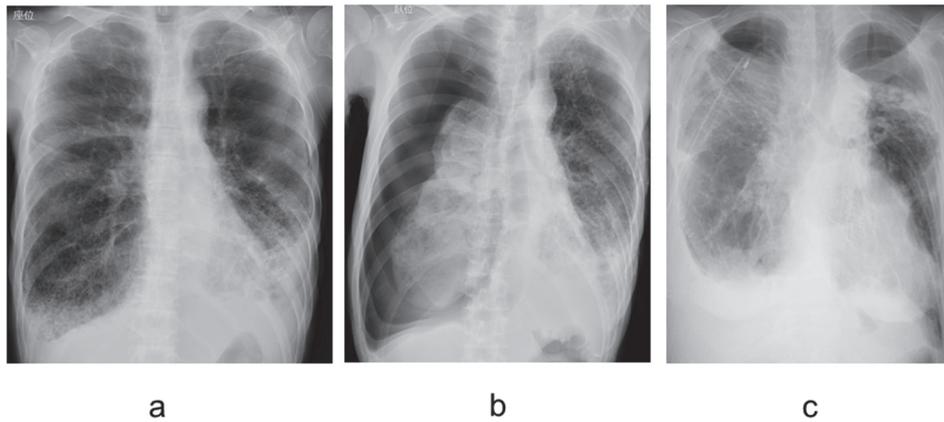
A chest radiograph on admission revealed bilateral interstitial shadow (a). A chest radiograph of right pneumothorax that developed the day after admission (b). A chest radiograph after conservative therapies (c). The right lung expanded but the leak did not stop.
